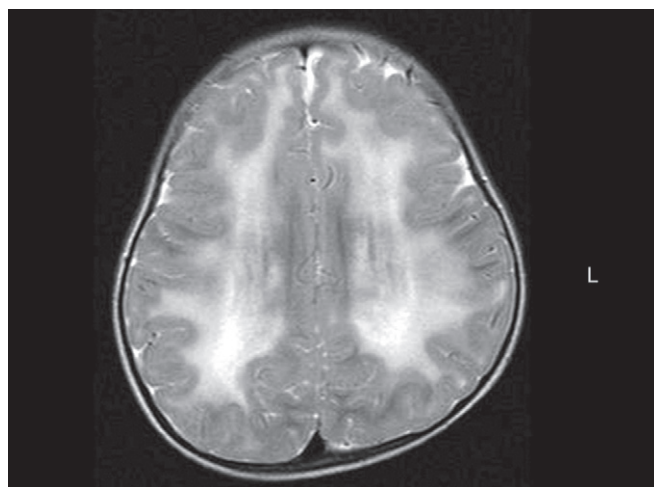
Merosinopathy MRI brain showing diffuse white matter changes
